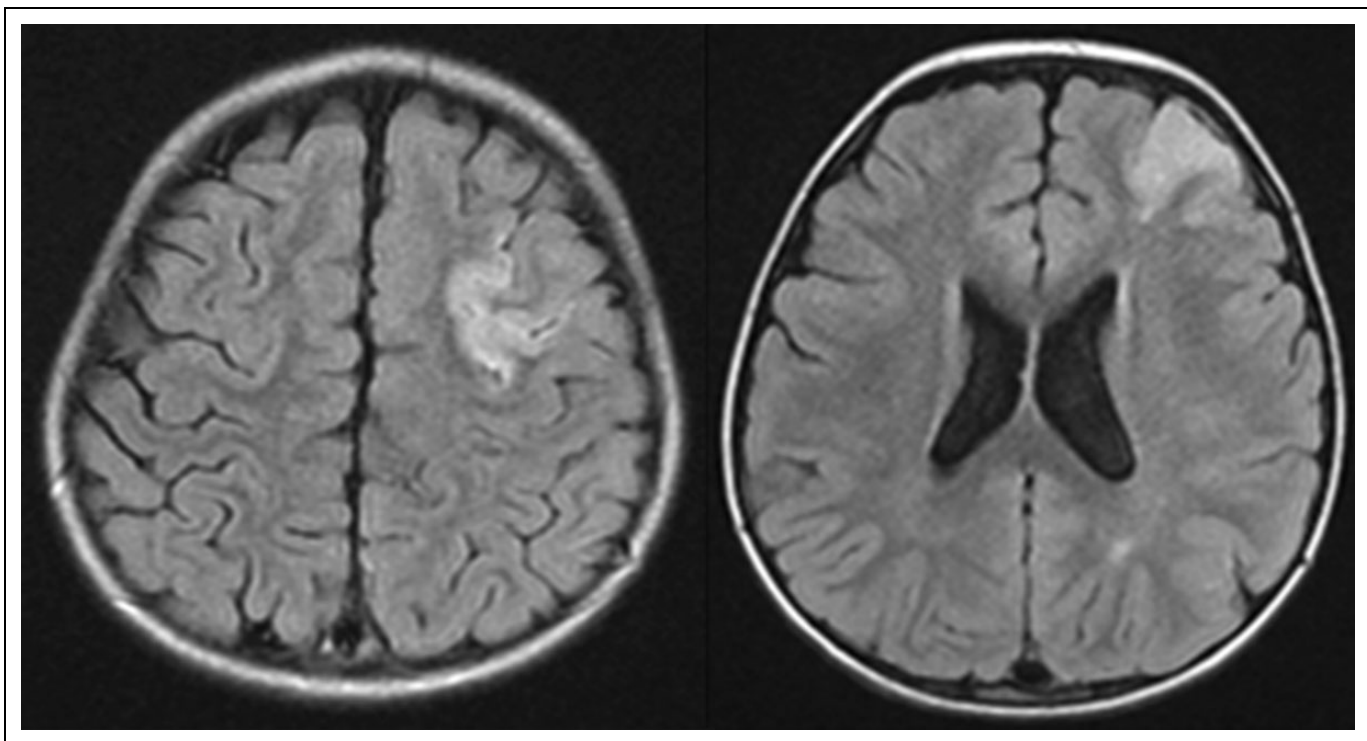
Magnetic resonance imaging (MRI) brain axial fluid-attenuated inversion recovery images demonstrate ischemic infarction in the left frontal and parietal regions.
